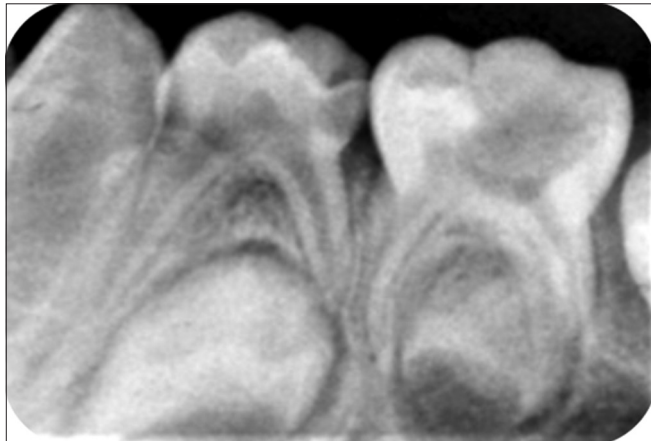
Pre-operative radiograph showing carious lower left first and second primary molars
